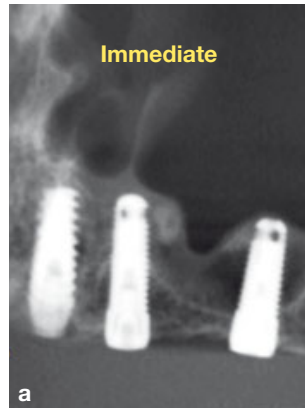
CBCT (sagittal view) of 56-year-old woman immediately after the selective sinus elevation and creation of the stable tent.
